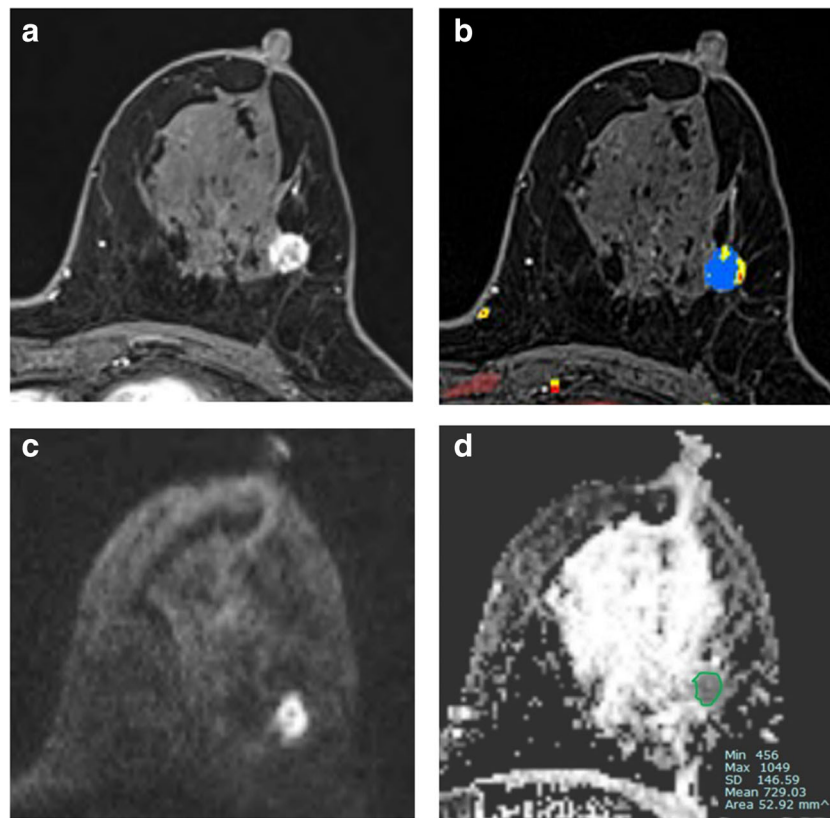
Preoperative breast magnetic resonance images of the left breast in 69-year-old woman with invasive ductal carcinoma. a Axial contrast-enhanced T1-weighted images show an irregular heterogeneously enhancing mass in the left breast. b A computer-aided diagnosis (CAD) color overlay map shows the enhancement kinetics of the tumor. Red, yellow, and blue areas indicate washout, plateau, and persistent enhancement patterns, respectively. c The auto-portfolio from the CAD system shows the delayed enhancement profiles of the breast cancer. The kinetic heterogeneity was 0.65. d Axial diffusion-weighted imaging (b value =
